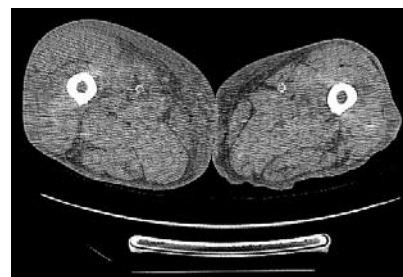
Transverse section CT scan of the lower extremities. Although there is edema throughout both thighs, it is greater on the right than on the left.
